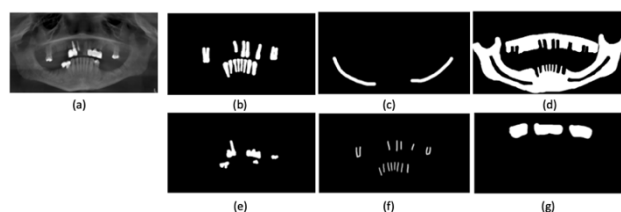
An example of panoramic images and six segmentations: (a)panoramic radiograph,(b)teeth,(c)major nerve,(d)bone,(e)restoration,(f)root canal,(g)sinus
